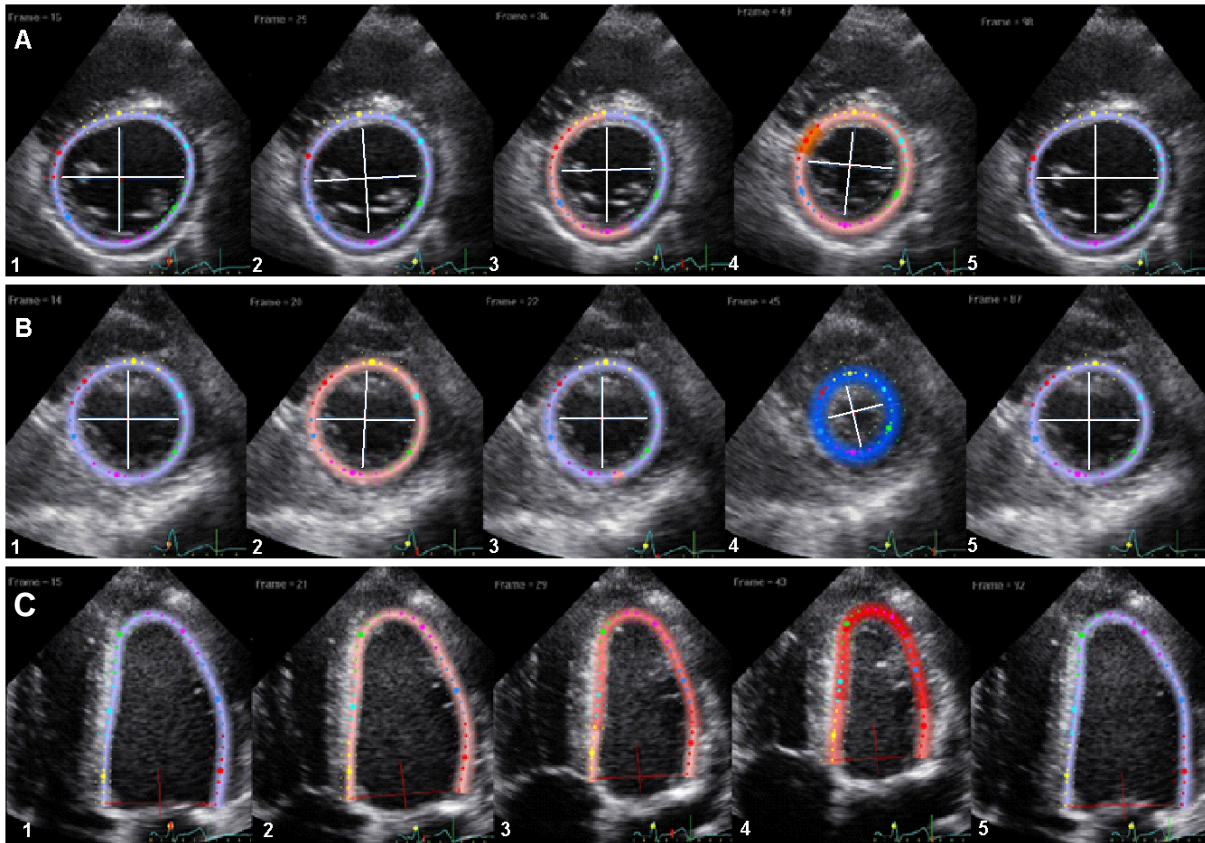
Example of two-dimensional left ventricular speckle tracking analysis. A coloured region of interest is superimposed on grey-scale video loops of LV parasternal short-axis images (A) at the basal level and (B) at the apical level. Examples show still images at (1): end-diastole, (2): isovolumic contraction, (3): mid-systole, (4): end-systole and (5): end-diastole. Blue region of interest indicates counter-clockwise rotation, red colours indicate clockwise rotation. White crosses demonstrate magnitude of rotation. Note the brief counter-directional rotation during iso-volumic contraction. The net difference in maximal counter-directional rotation of the LV base and apex at the end of systole (4) results in peak LV twist. (C) A region of interest is superimposed on the LV myocardium obtained from an apical four-chamber view to assess longitudinal strain. Blue colours indicate relaxed state at the end of diastole (1 and 5). Red colours represent increasing strain over the LV myocardium.
